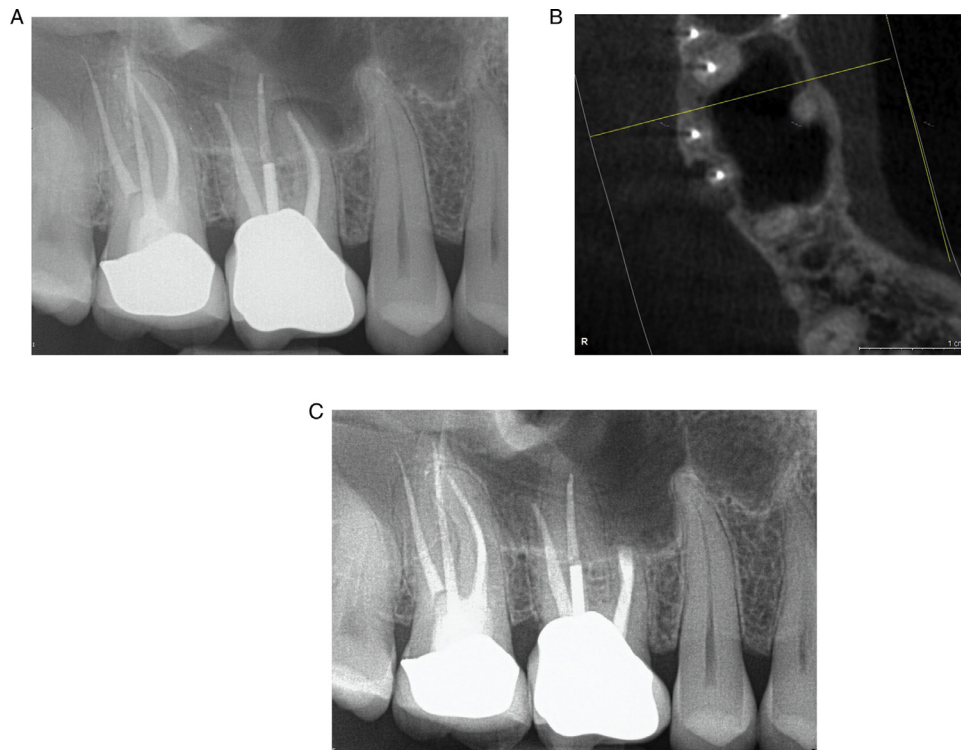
(A) Periapical radiograph showing a unilocular radiolucent lesion at the root apex of tooth 3. The tooth had been endodontically treated approximately 7 years previously. (B) Axial cone beam computed tomography section showing a unilocular radiolucent lesion. The mesiobuccal root apex exhibited a discontinuous buccal cortical plate with a hypodense region at the apical root end. Both the periodontal ligament and lamina dura were indistinct. (C) Periapical radiograph at 1-year follow-up examination.
